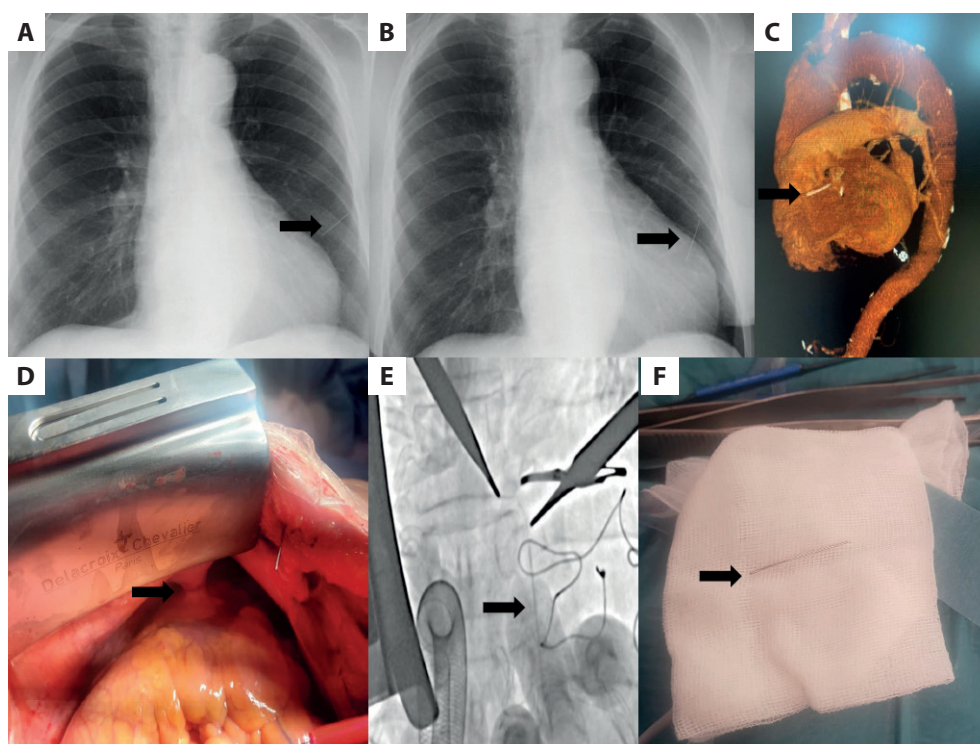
A. First chest X-ray: the needle in the subcutaneous tissue (arrow). B. Second chest X-ray: the needle in the pericardial sac (arrow). C. Computed tomography scan: the foreign body near outflow path of the right ventricle (arrow). D. Intraoperative image: fusion in the pericardial sac (arrow). E. Live X-ray image: confirmed localization of the needle (arrow). F. The needle after removal (arrow)
